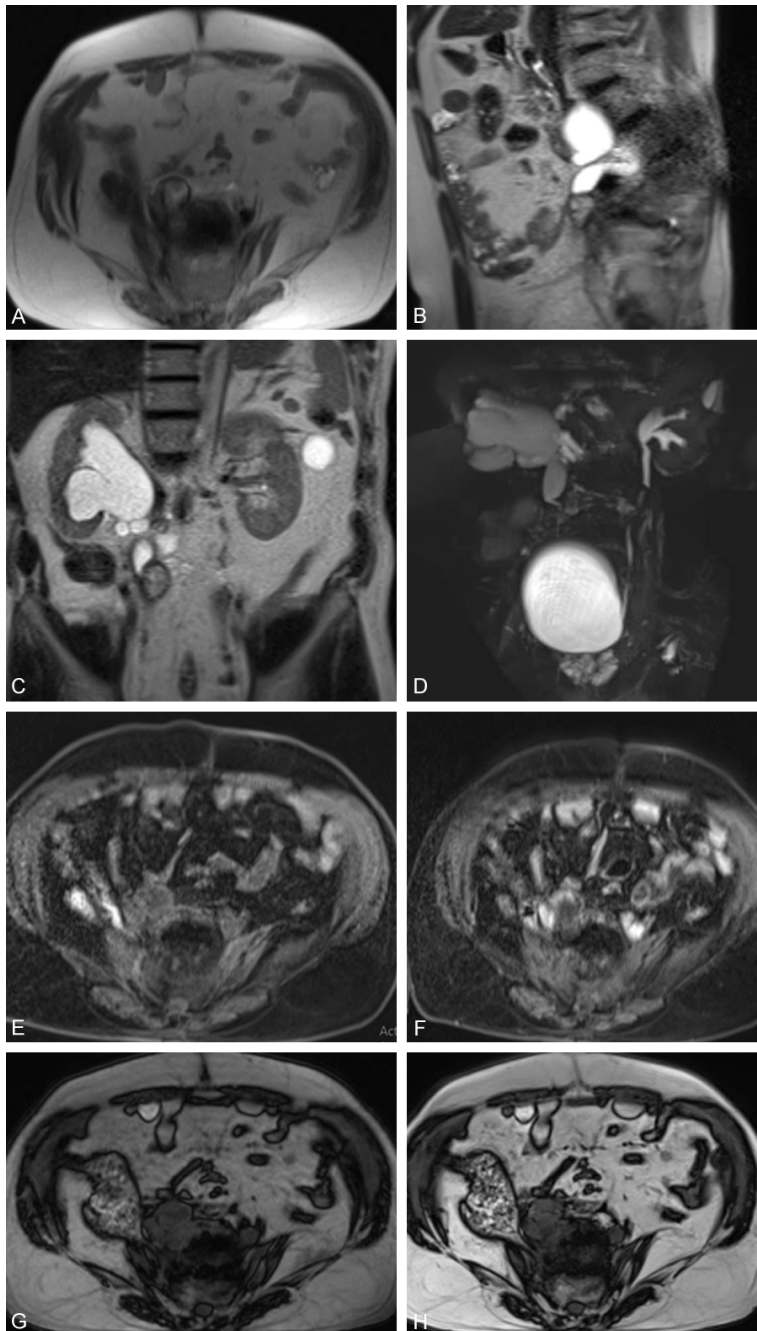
Abdominopelvic MRI with and without contrast. (A) Axial T2 HASTE, (B) Sagittal T2 HASTE, (C) Coronal T2 HASTE (D) MRU, (E) T1 fl2d, (F) T2 TRUFI, (G) T1 VIBE without contrast and (H) with contrast images show an intra ureteric lesion with in continuity to the spondylitis and minimal post contrast enhancement.
